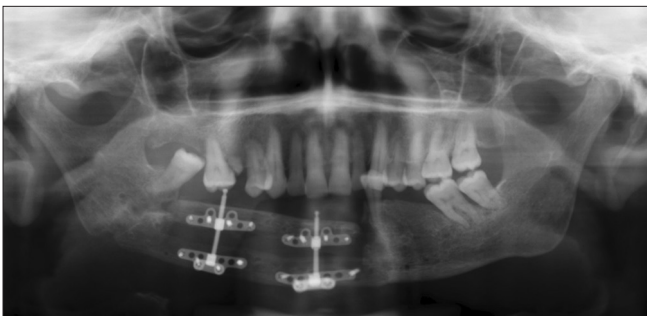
Distraction osteogenesis phase. Second radiographic control
